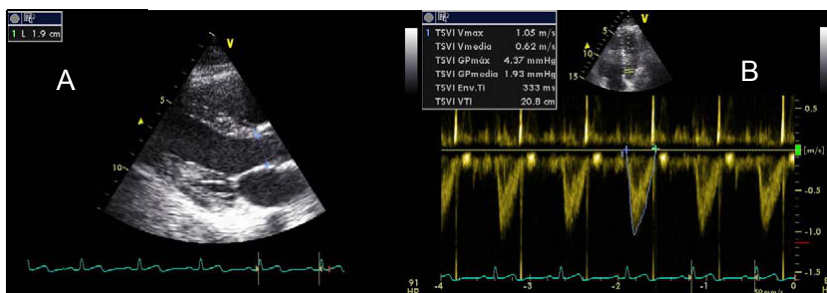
Example of an echocardiography of the heart. On the left, the aortic arch; on the right, the velocity time integral of the blood flow through the aortic arch. Image extracted from [Rom11].
